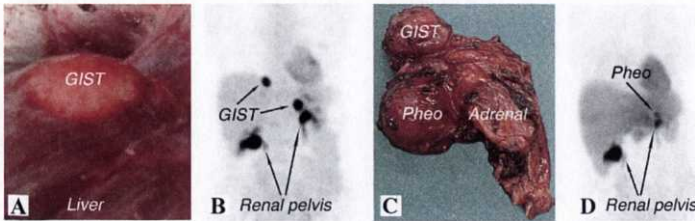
A small GIST liver metastasis (A). This tumour and a synchronous GIST were visualised by ^{18}F -FDG in the upper portion (B) of a time-glass shaped tumour adjacent to the left adrenal (C). The lower tumour portion was an extra-adrenal pheochromocytoma, imaged by ^{11}C -HED (D).
